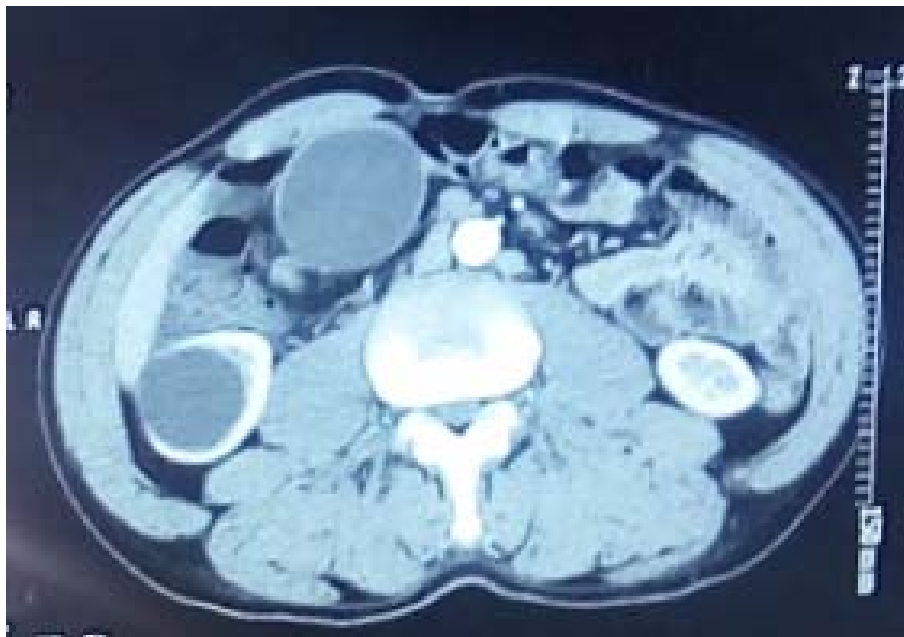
CT scan section showing the cystic mass with wall enhancement (thin arrow). Note the cyst on the lower pole of the right kidney (thick arrow).
